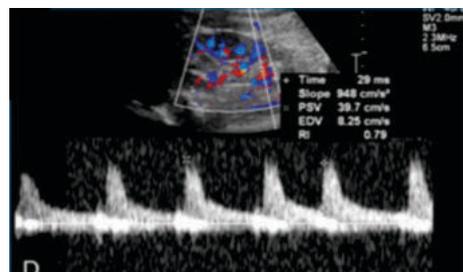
Case 1: On Color Doppler Examination of Right Kidney, Renal RI Appears Increased Measures 0.79
